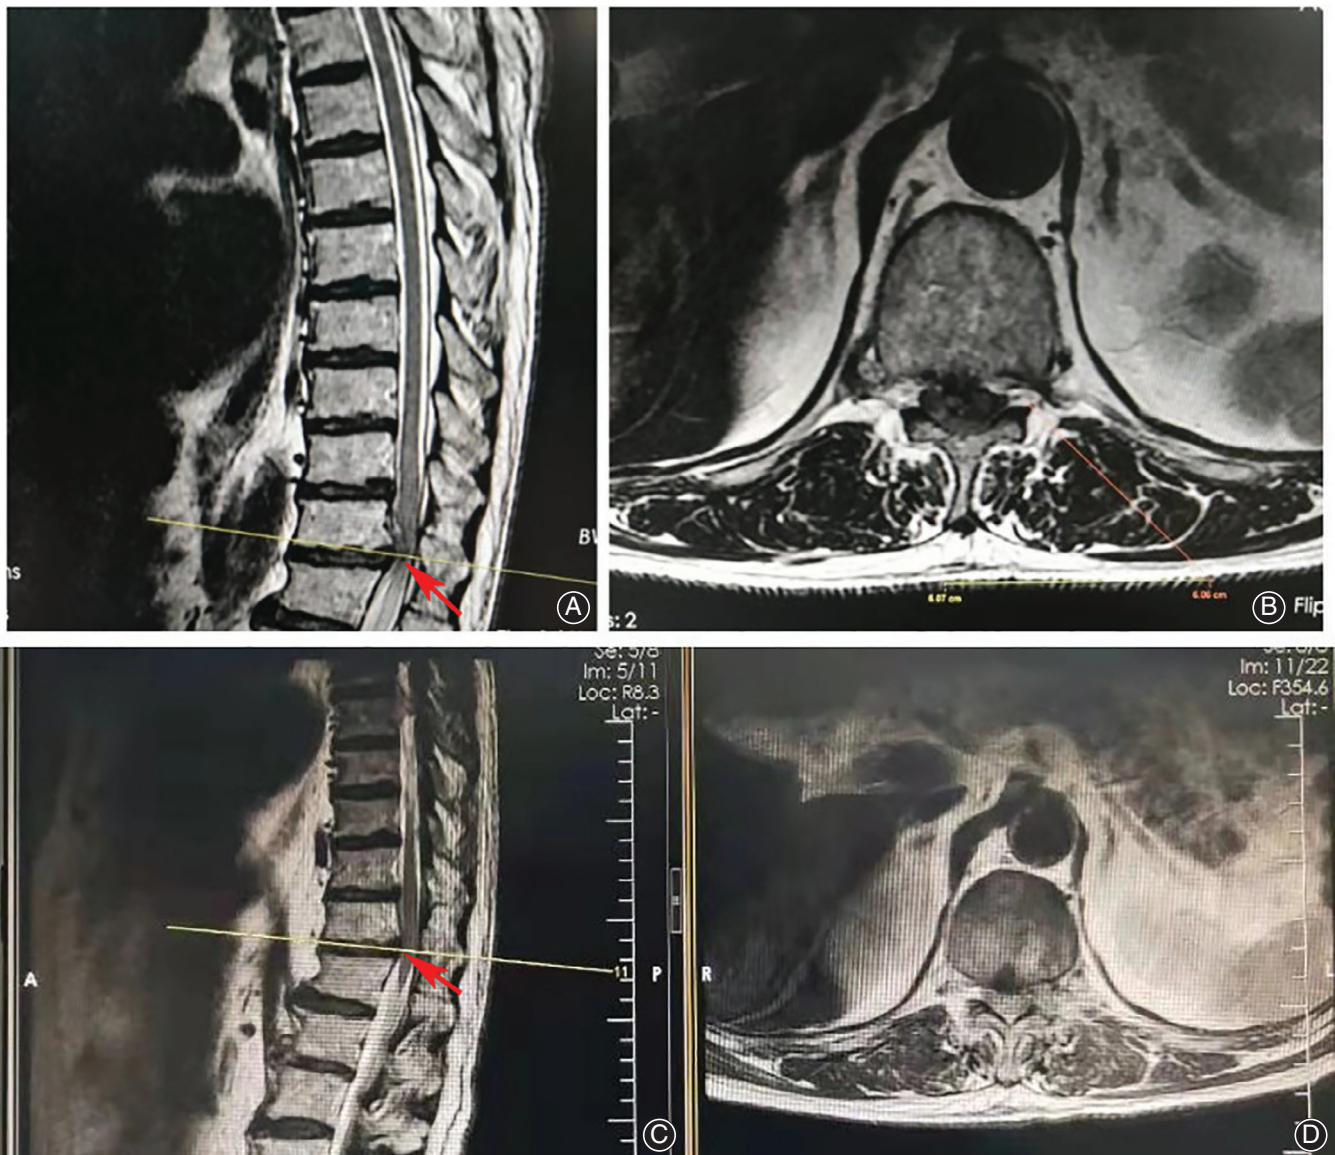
The patient (male, 64 years old) who underwent percutaneous endoscopic thoracic discectomy (T₁₁–T₁₂) had progressive deficit of the lower limbs in the context of pyramidal tract syndrome before the operation. (A) and (B) Preoperative MRI of sagittal and axial views, respectively, of the thoracic spine show the T₁₁–T₁₂ disc herniation. (C) and (D) Postoperative MRI indicated that the disc herniation was cleared and the decompression was successful.
